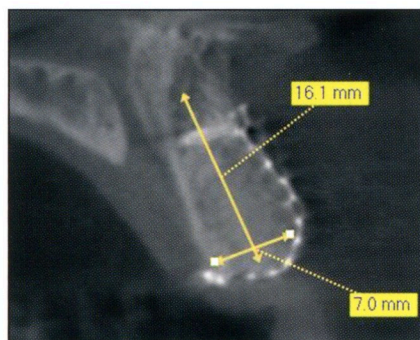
CBCT scan taken at 7 months confirmed excellent bone healing.
